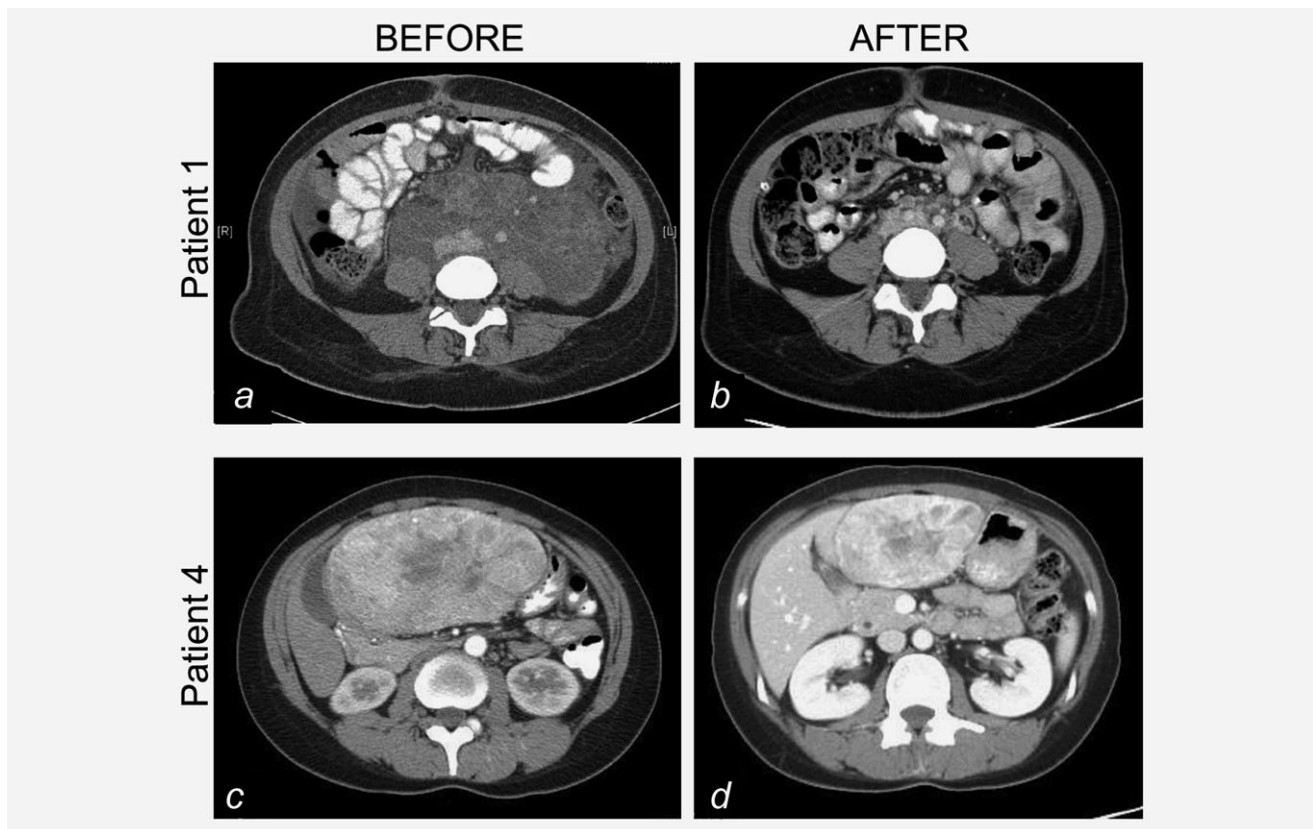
Computed tomography images of two patients (Patients 1 and 4) with PEComa at baseline (a and c, respectively) and after treatment with sirolimus for 6 months (b) or everolimus for 2 months (d).
